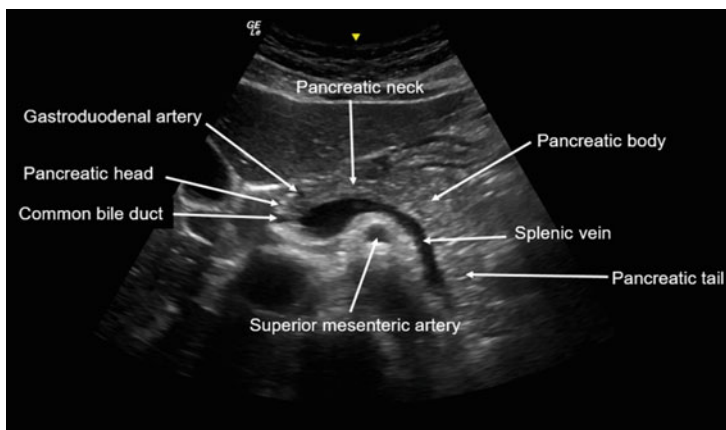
Ultrasound image of a normal pancreas. The pancreas is located posterior to the stomach
